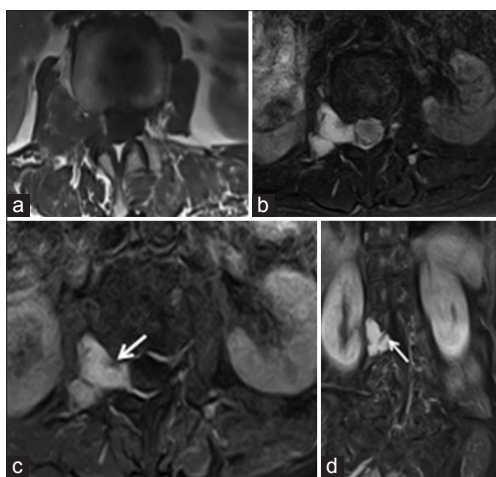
Preoperative magnetic resonance images at the level of L2/3 showing an irregularly-shaped, well-defined extradural lesion with paraspinal transforaminal extension that was hypointense on T1-weighted (T1W) (a) and hyperintense on T2W (b) and diffusion-weighted images. (c) Contrast-enhanced T1W images of transverse (d) and coronal sections showed the right L3 nerve root ventrally separated from the homogeneously enhanced tumor (arrow)
